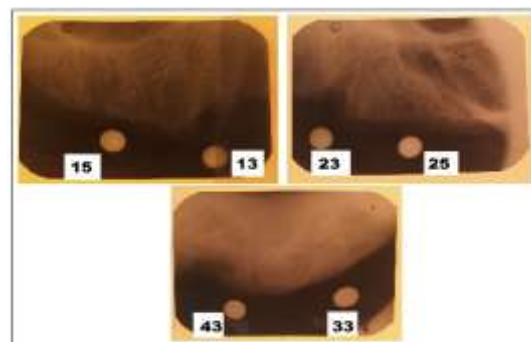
Periapical radiographs with 4 mm reference metal balls.
